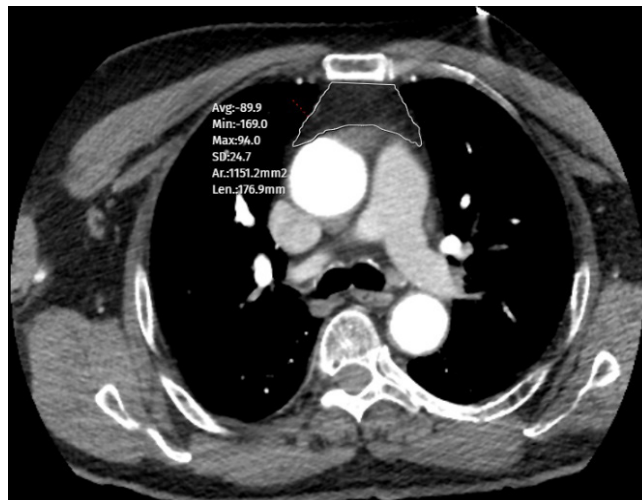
The measurement of the anterior mediastinal fat tissue area on the axial CT image.
